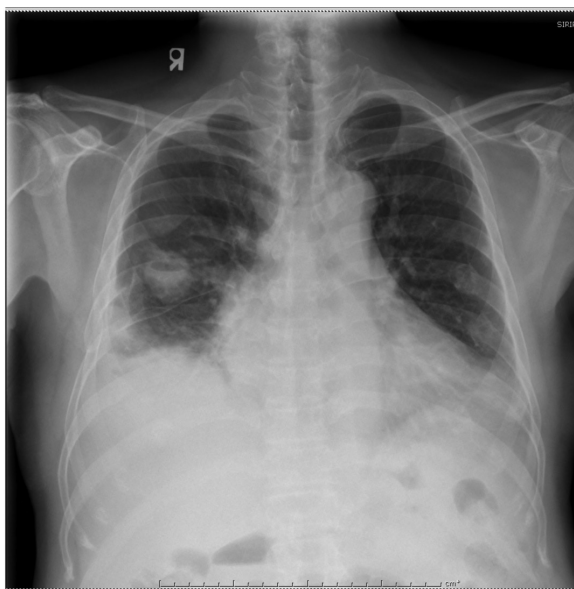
Chest X-ray posterior-anterior (PA) upright view showing a thick walled cavity with an air-fluid level in the right lung with blunting of the right costophrenic angle.
